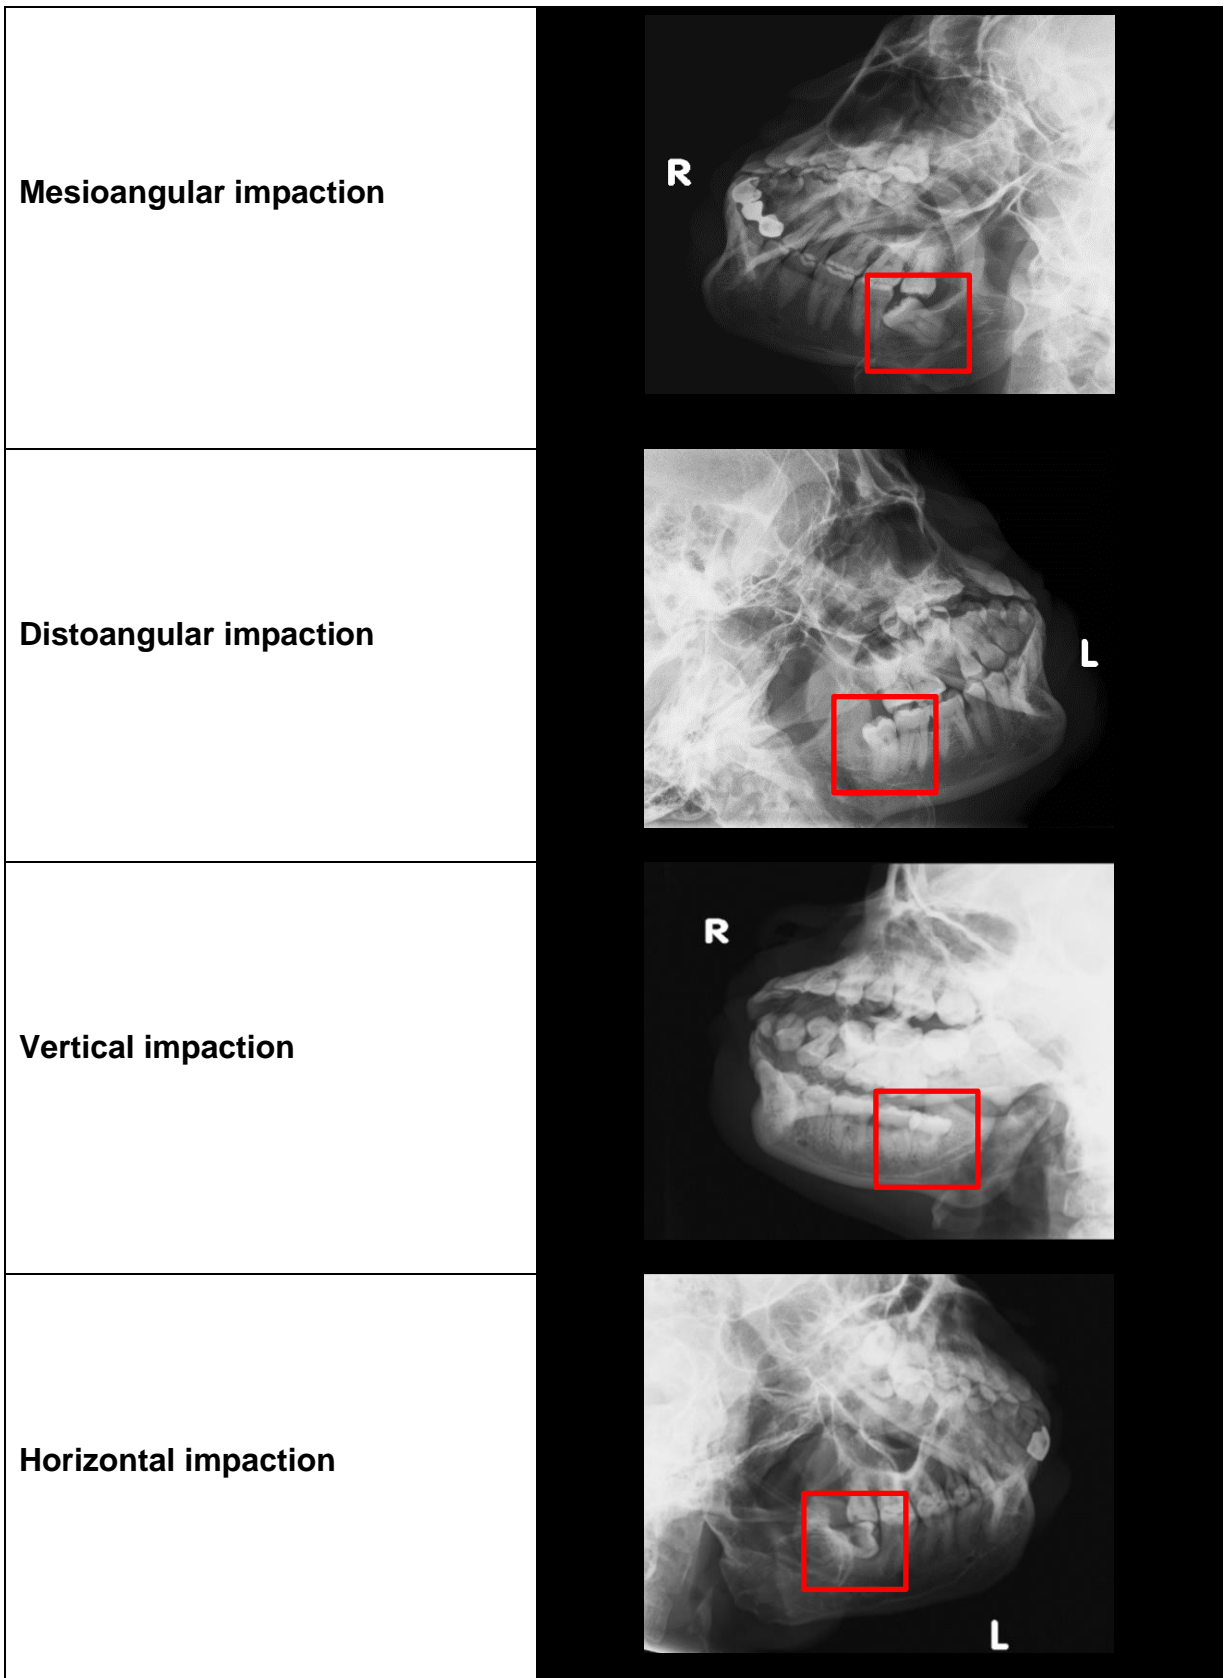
Mandibular third molar angulations shown on lateral oblique radiographs
